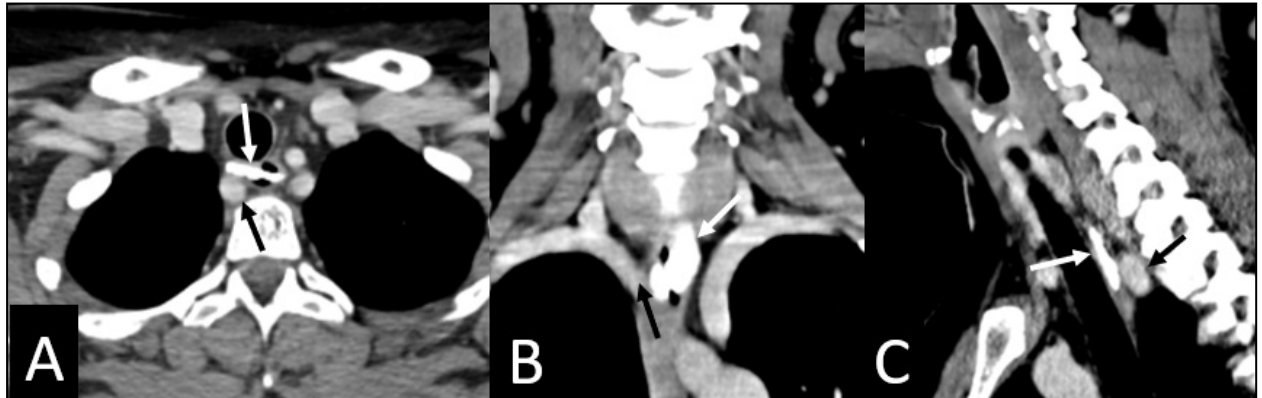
Contrast-Enhanced CT Neck. hyperattenuating intraluminal foreign body in the cervical esophagus (white arrow) and its direct continuity with the anomalous right subclavian artery (black arrows). A, axial view; B, coronal view; and C, sagittal view.
